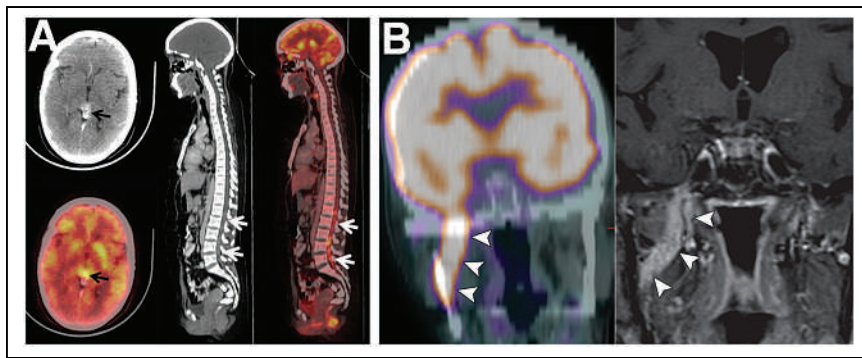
(A) Drop metastases in spinal canal from germ cell tumor of pineal gland. Head CT (top left) and ^{18}F -FDG PET (bottom left) show avidly enhancing hypermetabolic nodular lesion in pineal gland (arrows). Sagittal CT (middle) and ^{18}F -FDG PET/CT (right) show increased uptake in ill-defined densities in spinal canal extending from L1 to L5 (arrows). (Adapted from (58).) (B) Perineural tumor spread along V3 (mandibular) nerve. Coronal ^{18}F -FDG PET/CT (left) and contrast-enhanced T1-weighted fat-saturated MRI (right) show intense ^{18}F -FDG accumulation and abnormal enhancement along V3 (arrowheads). (Adapted with permission of (60).)
